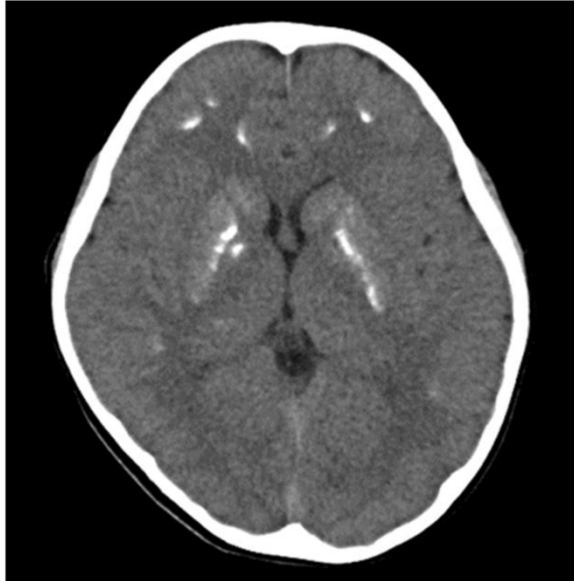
Computed tomography scan of the head showing multiple calcifications in the basal ganglia and the frontal cortex.
